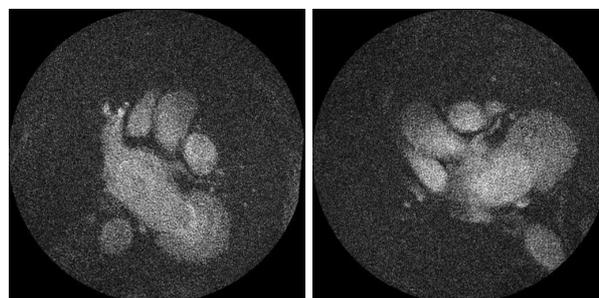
MRI acquisitions of coronary tree.
